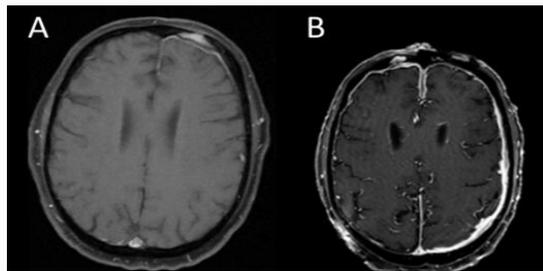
A) Axial T1 post-contrast MRI image from 2004 demonstrating an enhancing mass-like skull-based lesion in the left frontal convexity with underlying dural enhancement along the left frontal lobe. B) Axial T1 post-contrast MRI image from 2019 demonstrating diffuse extra-axial enhancement along the entire left frontal convexity, falx, and right frontal convexity.
